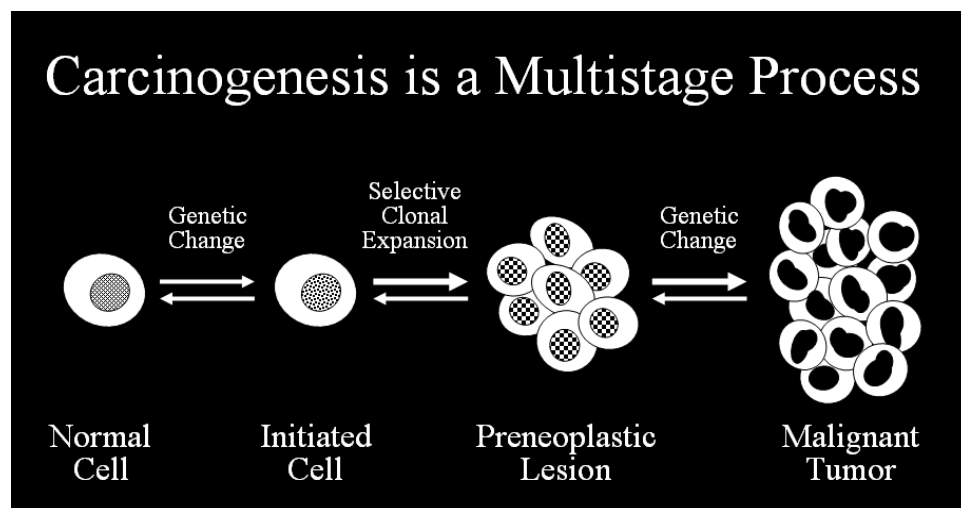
Carcinogenesis. Carcinogenesis occurs in four stages: initiation, promotion, conversion, and progression. Cells are primed for neoplastic transformation when an initiating event directly affects DNA. Exposures to chemical carcinogens or x-rays are examples of initiating events. Identifying an initiated cell is exceptionally difficult. Continued progression down the carcinogenic pathway involves hyperplasia and the linear evolution of an increasingly aberrant and aggressive collection of abnormal cells with loss of normal control mechanisms.
